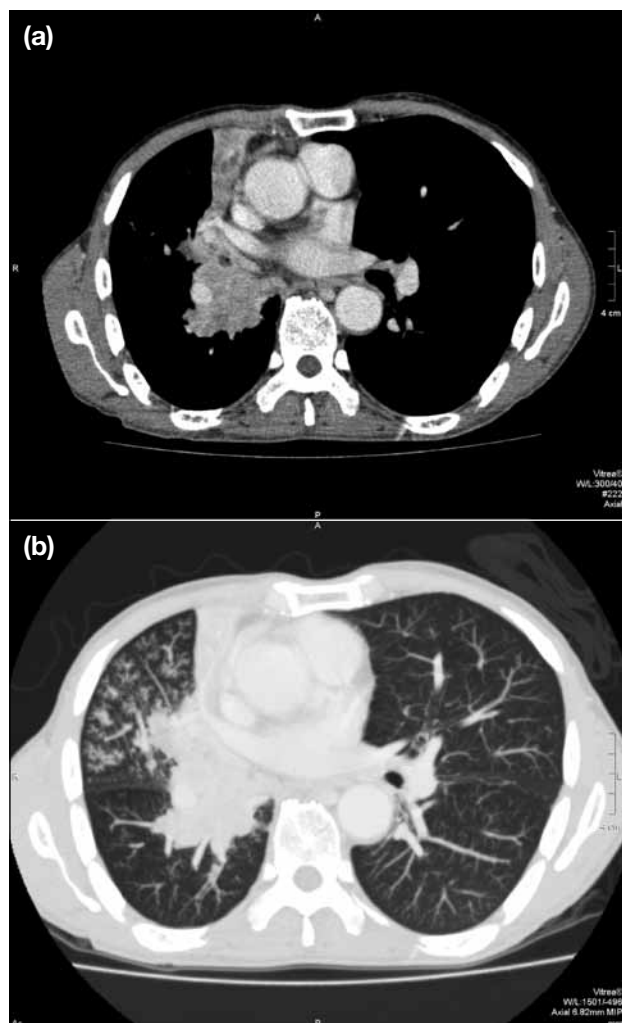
A male adult with lung carcinoma: axial post-contrast computed tomographic scans of thorax (a) in a soft tissue window showing a right-sided abnormal soft tissue mass compatible with lung carcinoma, and (b) in a lung window with maximal intensity projection showing tree-in-bud opacities in the right middle lobe.
